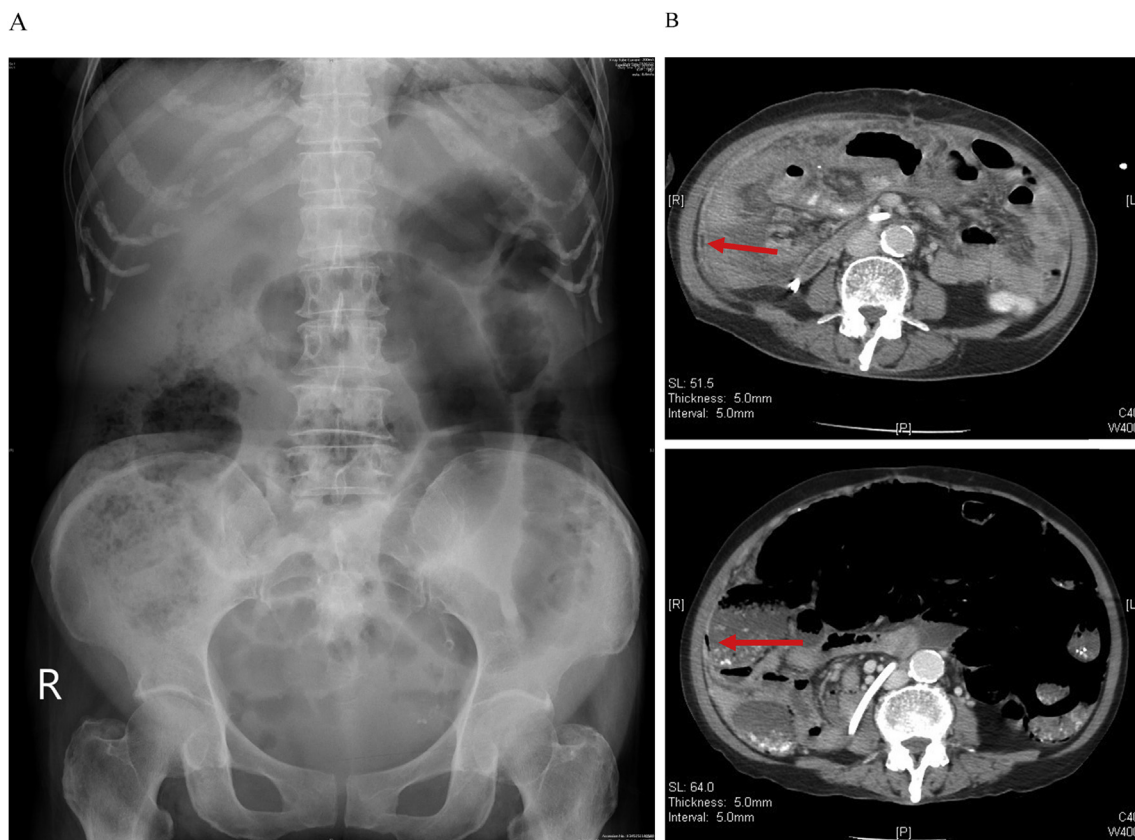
Images of the patient consistent with tuberculous peritonitis. (A) Kidney, ureter, and bladder X-ray showing increased bowel gas. (B) Computed tomography indicating thickened peritoneum with mild ascites and air collection (arrow) in the bowel wall from the jejunum to the ascending colon and suspected pneumatosis intestinalis.
